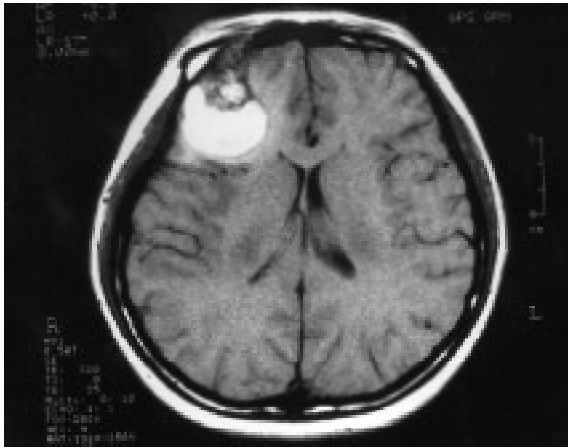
Axial T1-weighted MR image.
